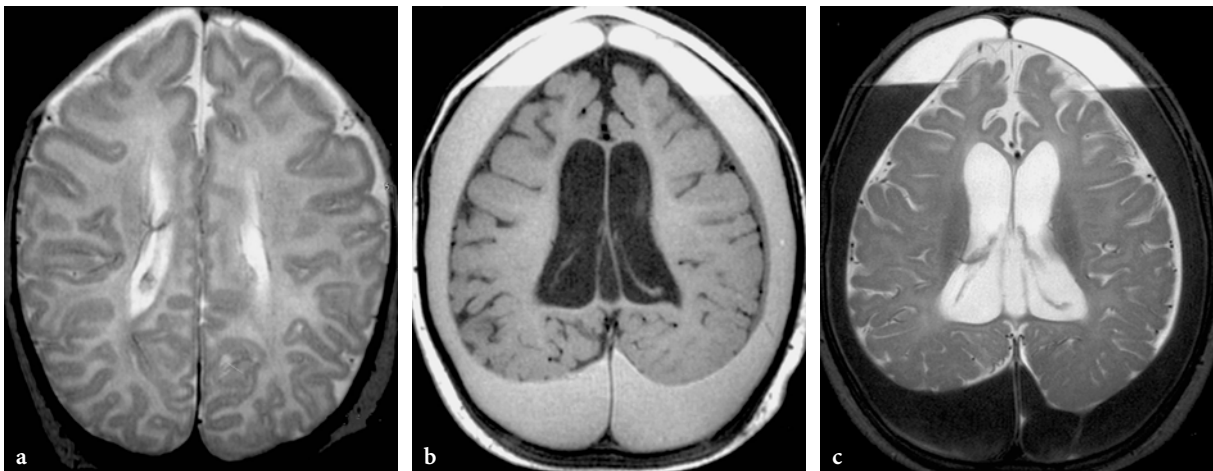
MR imaging findings in Menkes disease (courtesy of Dr. T. Huisman, Zurich, Switzerland). a Axial T2-weighted images at the age of 20 days. Essentially normal study. b, c Axial T1- and T2-weighted images of the follow-up examination at the age of 13 months. Prominent delay of myelination in conjunction with severe brain atrophy. Bilateral spontaneous subdural hematomas with fluid-fluid levels
